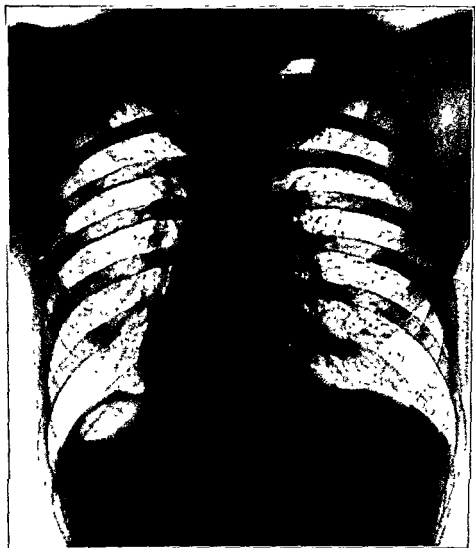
A span of three years since the x-ray in Fig. 61. There has been no change in the x-ray. The patient has been at work the past three years.
